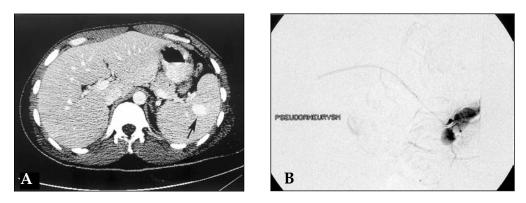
A 31-year-old patient presented 10 days after blast injury with a splenic pseudoaneurysm that was seen on routine follow-up CT (A). An angled glide catheter (Terumo, Ann Arbor, MI) was advanced to the splenic hilum and into the pseudoaneurysm (B). The feeding artery was embolized using several coils (Tornado, Cook Medical, Bloomington, IN).
